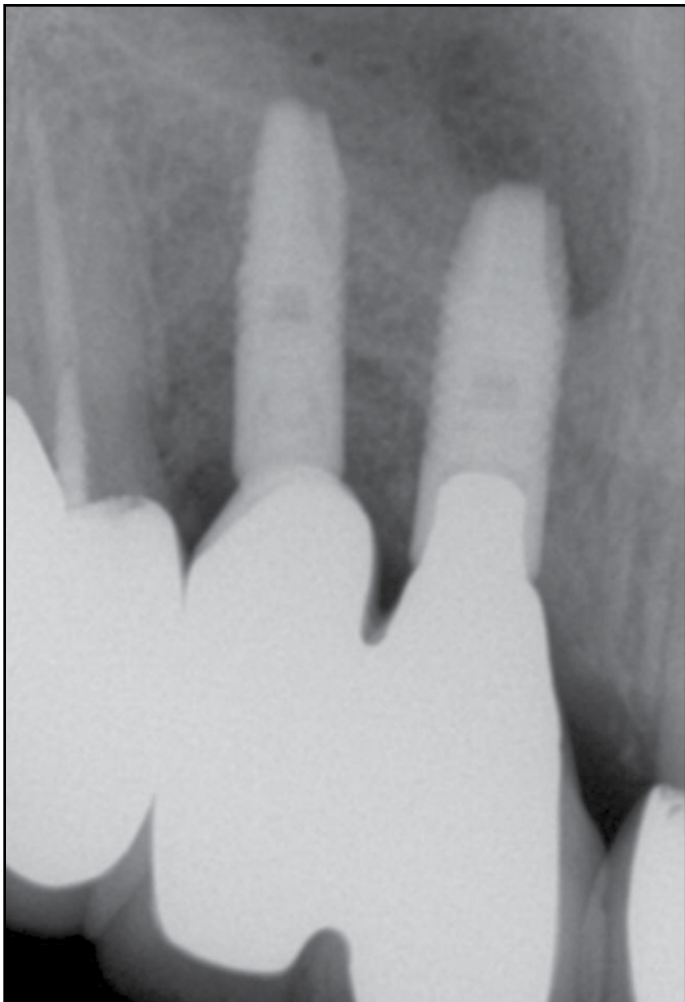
Periapical radiograph taken approximately 2 weeks after delivery of the final restorations. Excellent bone regeneration associated with the two implants, #7 in particular, is appreciated.
